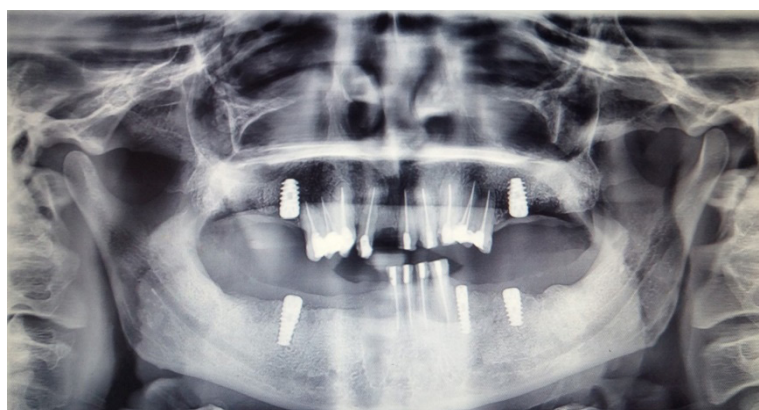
Post-operative radiographic view after three months showing implants placed in relation to #16, #26, #36, #34, and #46.
